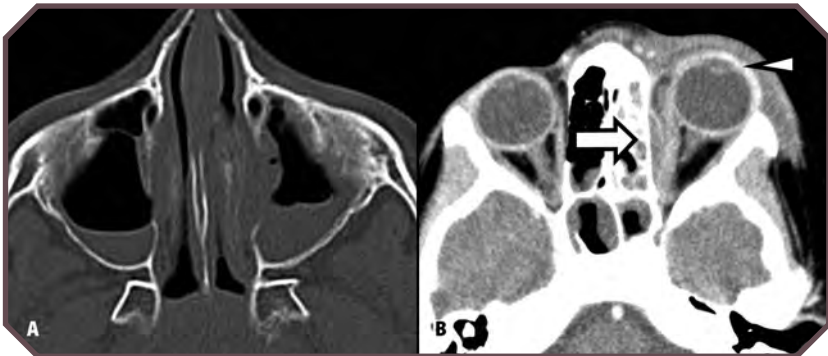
Maxillary and ethmoid sinusitis complicated by orbital abscess. A. Axial computed tomographic (CT) bone window image shows bilateral maxillary sinus fluid levels. B. Axial contrast-enhanced CT soft-tissue window image demonstrates left ethmoid and sphenoid partial opacification in addition to left preseptal swelling (arrowhead), indicating cellulitis, proptosis, and a subperiosteal abscess (arrow).
